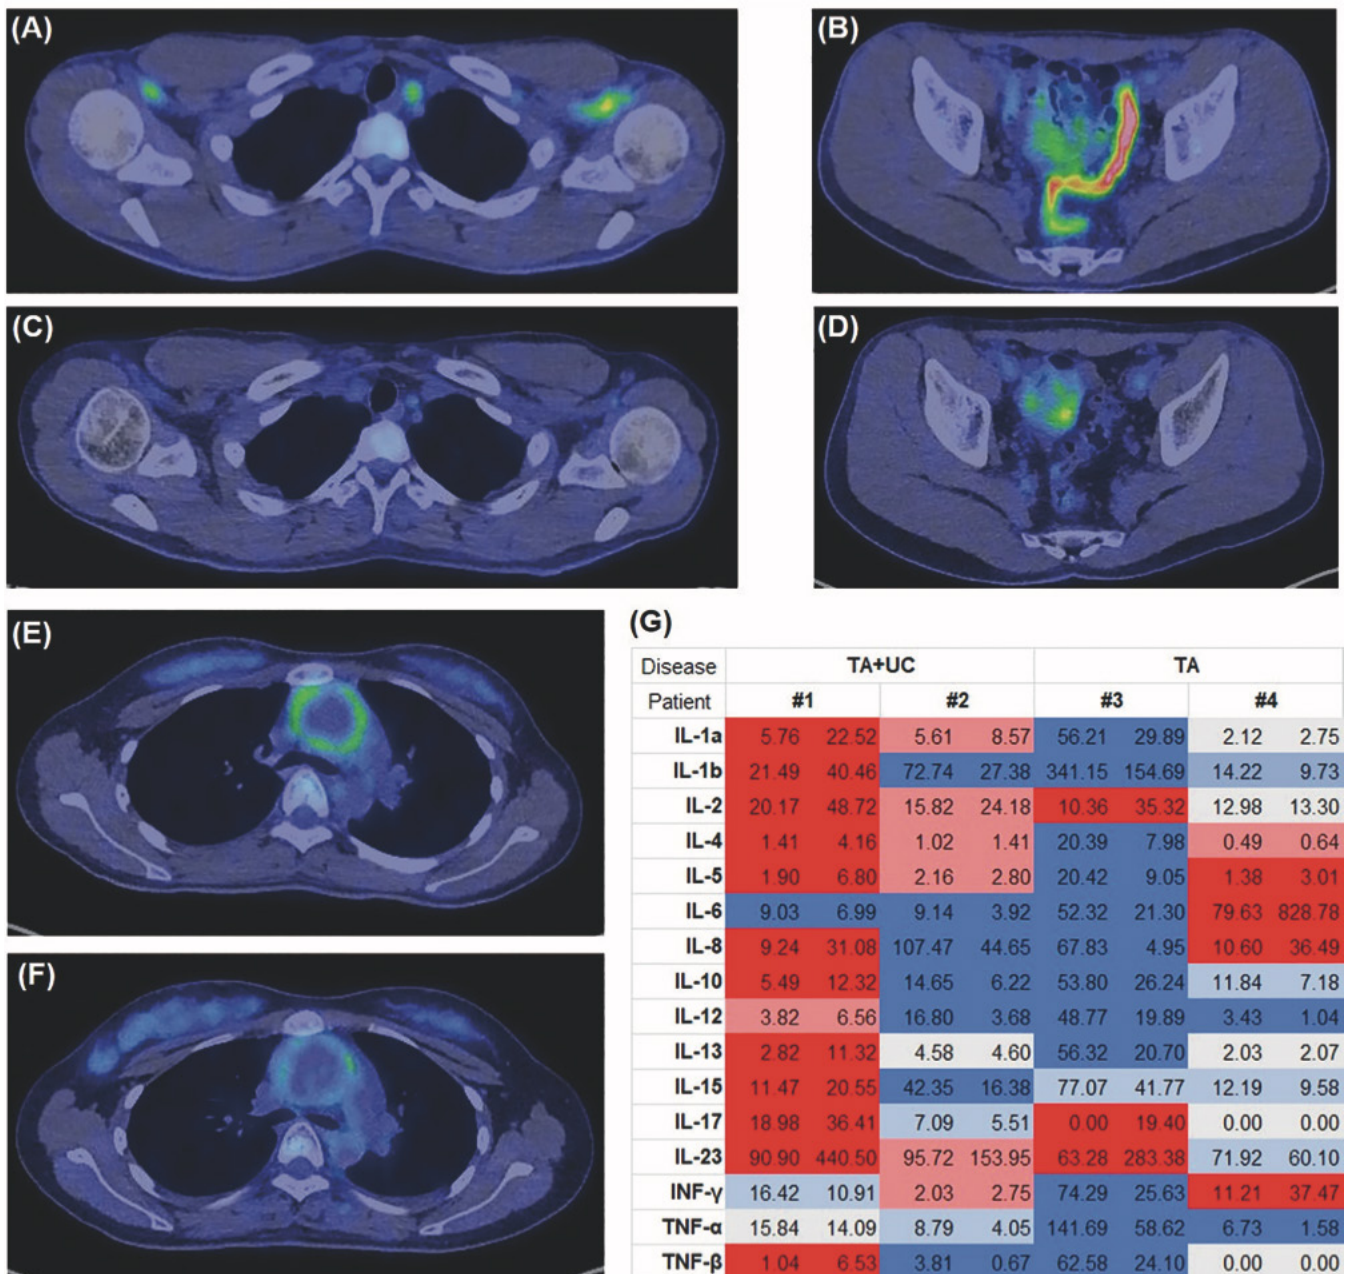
The interval changes of PET-CT and cytokines. PET-CT in the chest (A) and pelvis (B) recorded before induction and during tofacitinib monotherapy (C, D) in a male patient (patient #1) with refractory ulcerative colitis to infliximab. Chest PET-CT before (E) and after (F) induction in a female patient (patients #2) with severe arterial valvar regurgitation. Cytokine changes (in pg/ml) before induction therapy and during the maintenance phase in two patients with TA and UC and a patient with TAK alone positive (patient #3) or negative (patient #4) for HLA-B52 (G). The values in the left and right columns in corresponding to patient represent the serum value of each cytokine measured before induction therapy and maintenance, respectively. Cytokines highlighted in red indicate elevation after treatment (thick: approximately more than 2 folds, thin: less than 2 fold), blue highlights indicate a decrease (thick: approximately more than 2 folds, thin: less than 2 fold), and gray highlights indicate almost unchanged values.
